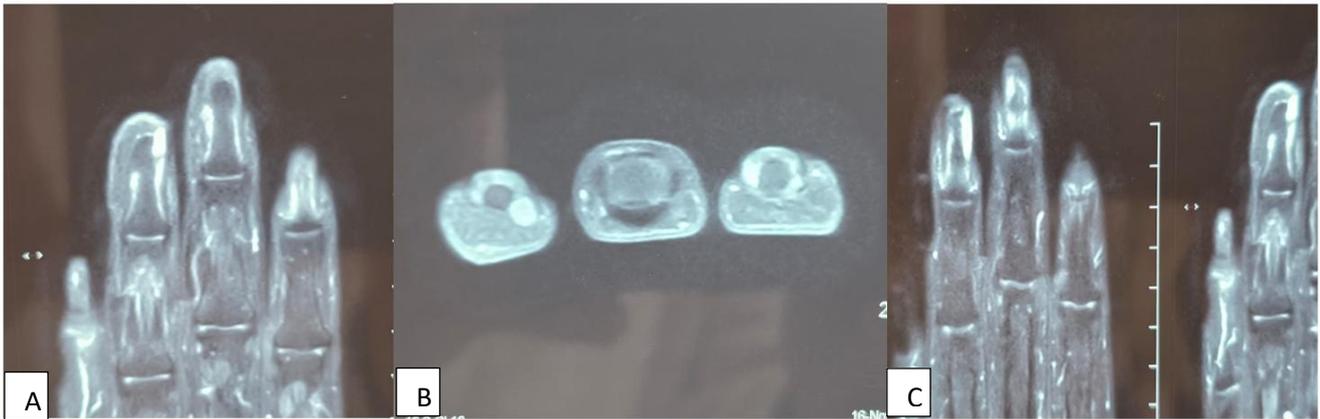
(A-C): MRI image showing high signal intensity and location of tumor
